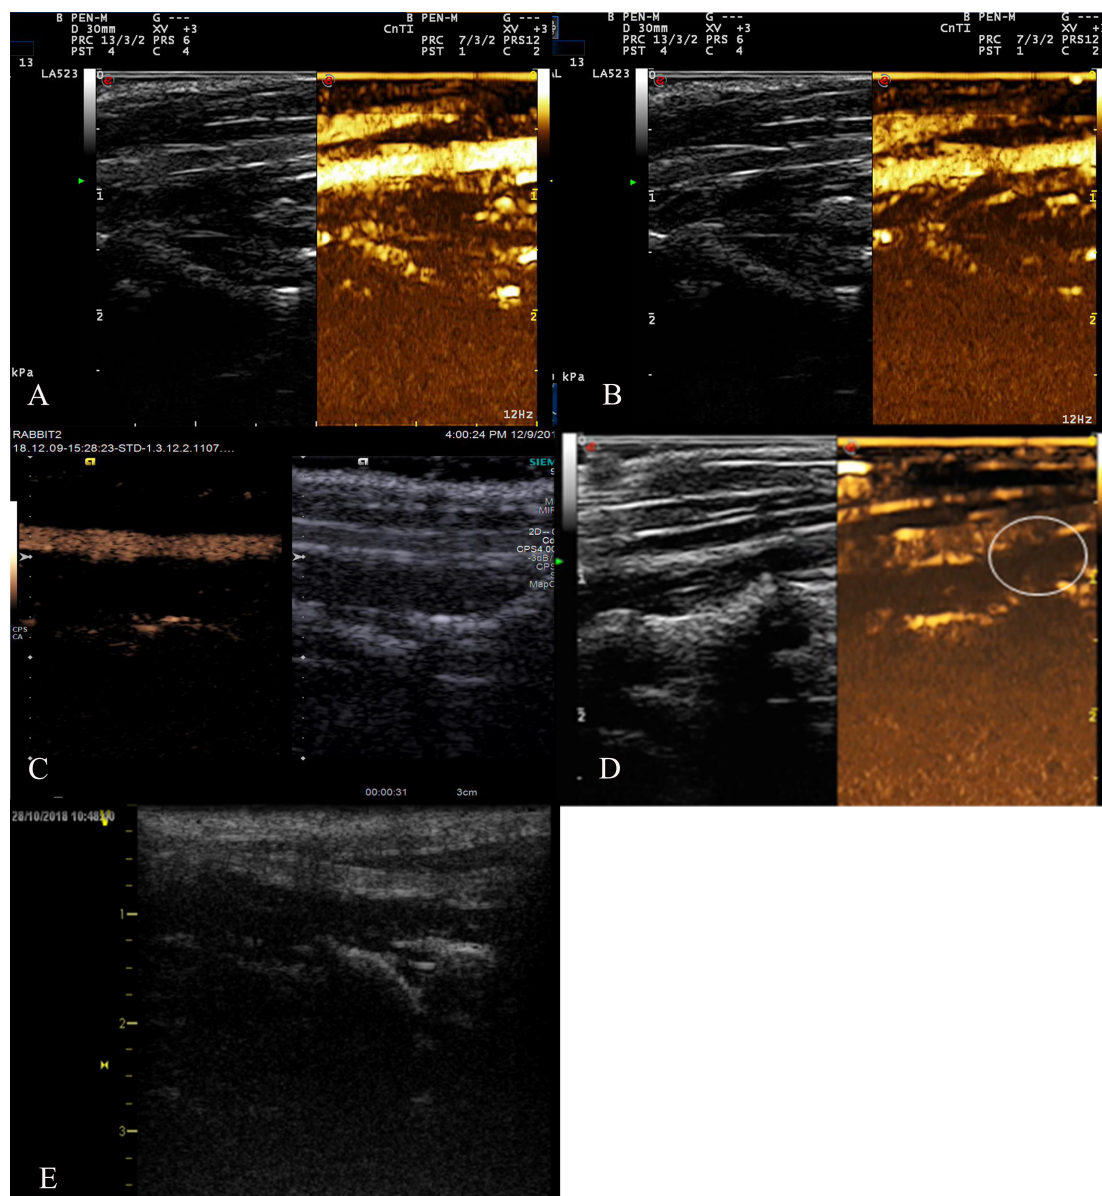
Rabbit carotid artery contrast-enhanced ultrasound. (A) Image showing the anti-VCAM-1 nanometer contrast agent group with short linear enhancement in the plaque. (B) Image showing the nanoscale contrast agent group with dot enhancement in the plaques. (C) Anti-VCAM-1 sonovi group. (D) SonoVue group; dot enhancement was observed in all plaques. (E) Control group; no contrast agent sonogram is observed in the lumen.
